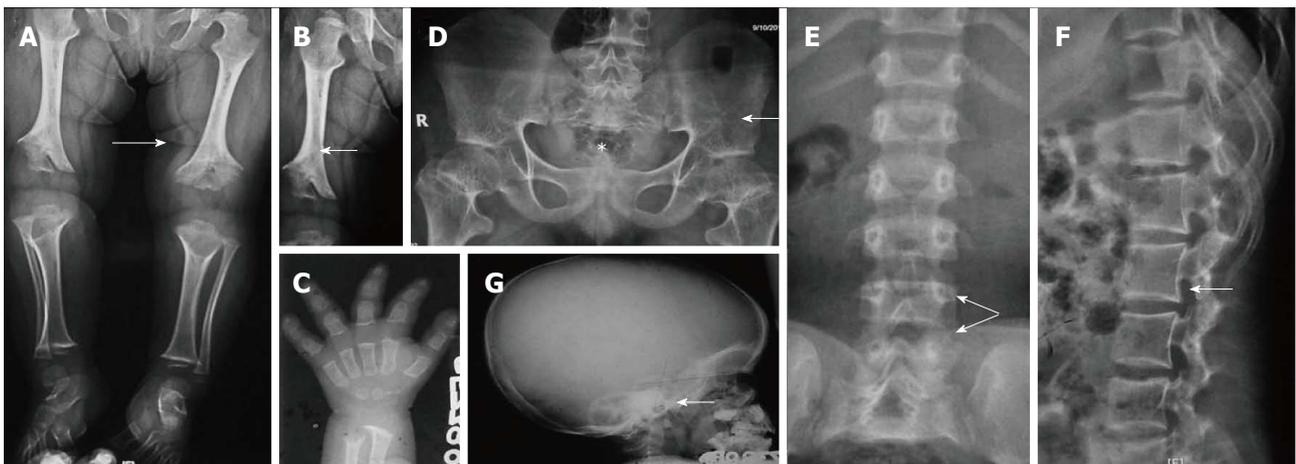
Achondroplasia. Radiograph of lower limbs (A, B) shows bilateral rhizomelic shortening with metaphyseal flaring (arrow, A) and chevron deformity in femur (arrow, B). Note trident hand appearance in (C). Radiograph of pelvis (D) shows short and broad pelvis (*), horizontal acetabuli (arrow) and round iliac wings. Radiographs of spine (E, F) show narrow interpedicular distance in lumbar spine (arrow, E) and posterior scalloping and thick, short pedicles (arrow, F). Radiograph of skull (G) shows enlarged cranial vault with narrowed foramen magnum (arrow).
